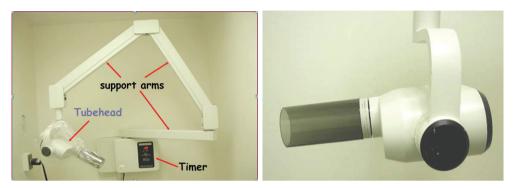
X-ray Tube Head and Flexible Arm Assembly after www.slide sheare. com, 2017
